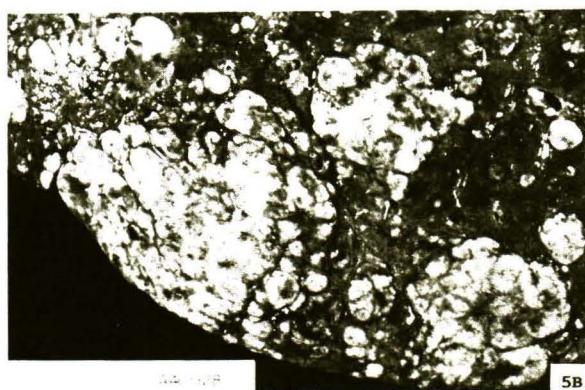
Multiple tumor nodules in the liver demonstrated by CT scan (A) and gross examination at autopsy (B).
